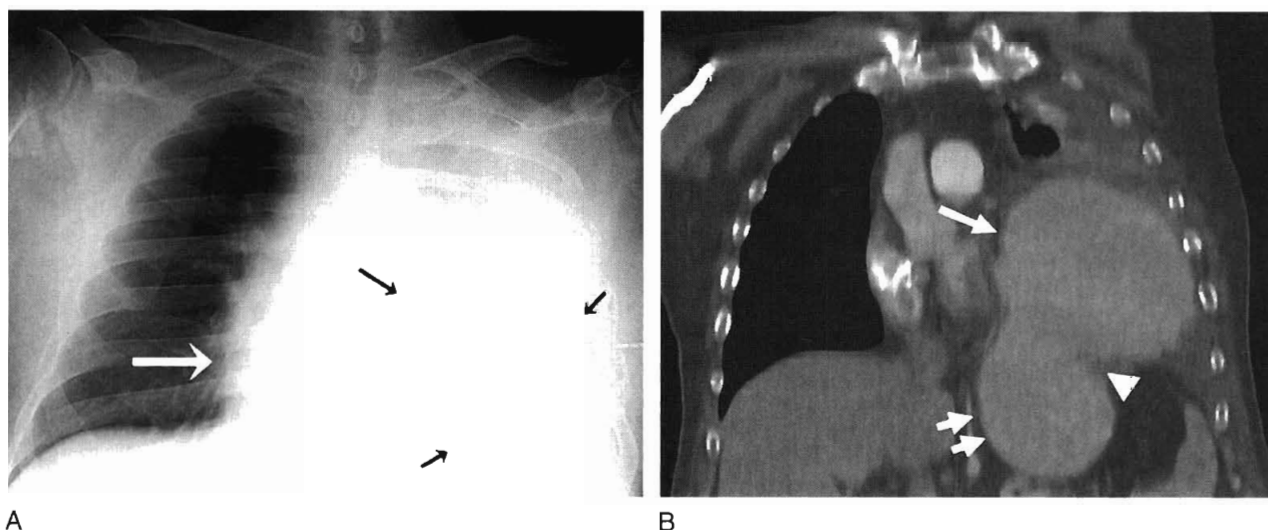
A 48-year-old man involved in a motor vehicle crash sustained a diaphragmatic injury. A, Bedside chest radiograph shows diffuse opacity in the left hemithorax and rightward mediastinal displacement (*white arrow*). A round lucency representing the gastric bubble is present within the opacified left hemithorax (*black arrows*). B, Coronal CT re-formation shows partial herniation of the stomach (gastric fundus [*single arrow*] and gastric body [*double arrows*]) into the chest through a large defect in the diaphragm (*arrowhead*).
